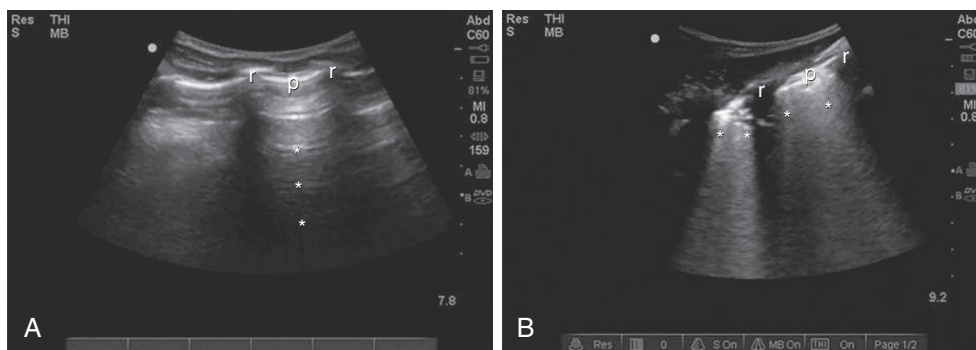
■ Ultrasound diagnosis of pulmonary contusion. A, Ultrasound image of the normal lung showing ribs (*r*) and the pleural line (*p*) with A-lines (*asterisks*), which are horizontal reverberation artifacts at equal distances. B, Ultrasound image of the contused lung showing ribs (*r*) and the pleural line (*p*) without A-lines. Instead, there are vertical hyperechoic artifacts known as B-lines (*asterisks*), which arise from the pleural line and erase the normal A-line pattern. (From Stone MB, Secko MA: *Bedside diagnosis of pulmonary contusion*. *Pediatr Emerg Care* 25:854, 2009.)
